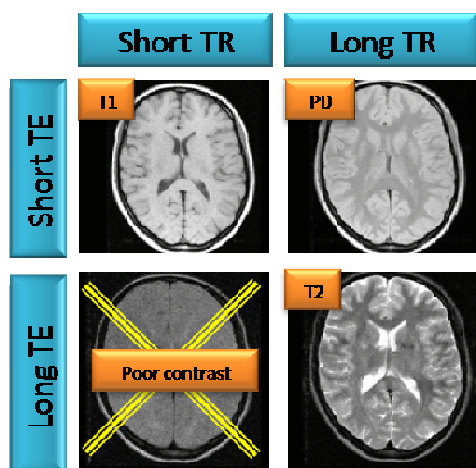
The four classes of MRI images obtained by varying TR and TE.²³
